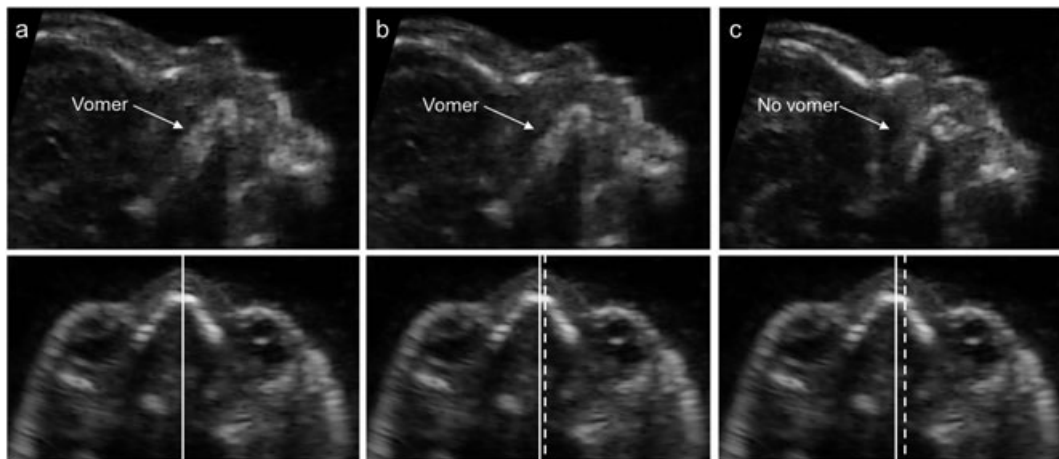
Ultrasound images from a trisomy 21 fetus obtained with the use of tomographic ultrasound imaging demonstrating the sagittal and the corresponding transverse plane of the fetal head at the level of the two eye sockets in the exact midsagittal plane (a) and in parasagittal planes at a distance of 1 (b) and 2 mm (c) from the midline
